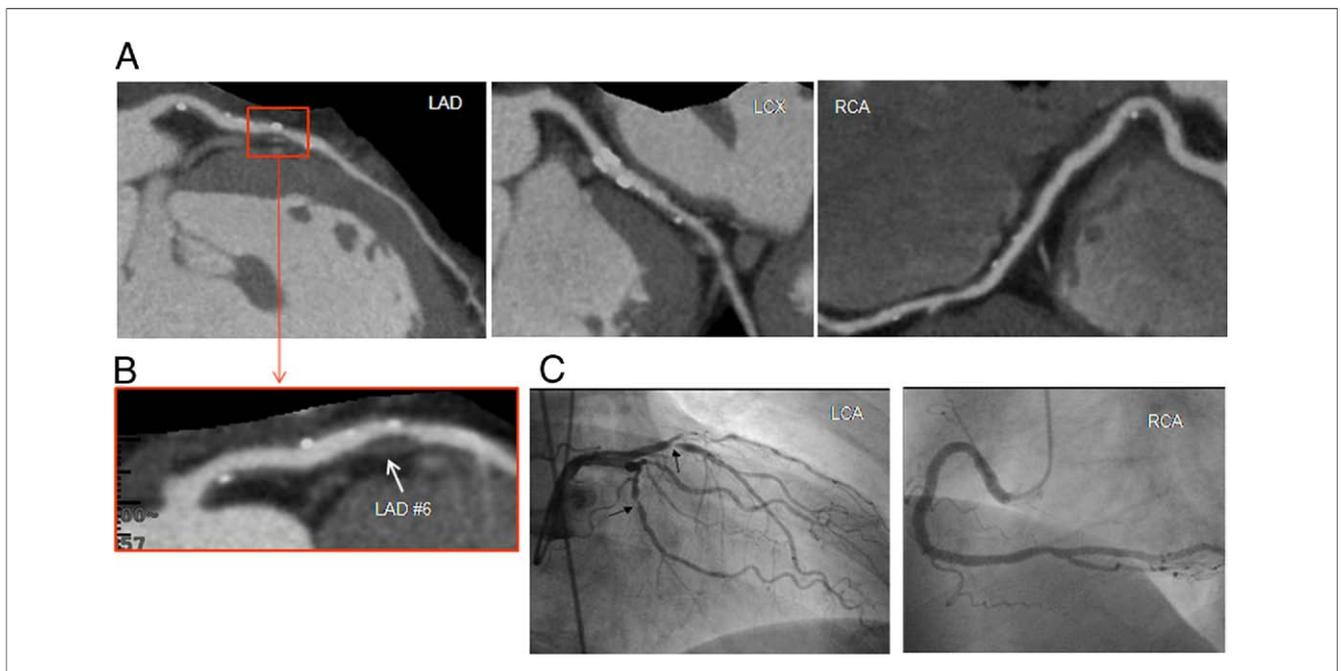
Example of a Patient With ACS 6 Months After CT Angiography
